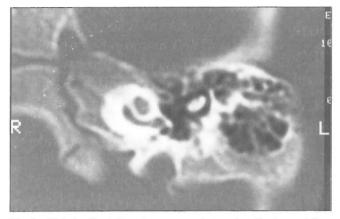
CT of patient K.: a hammer and dressing block are determined by a unified conglomeration
